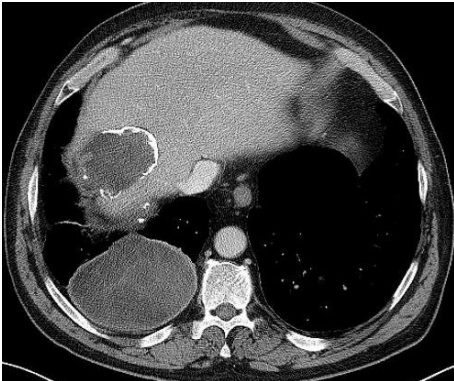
Preoperative chest computed tomography image: Diaphragmatic hydatid cyst and old liver cystic lesion is seen.
